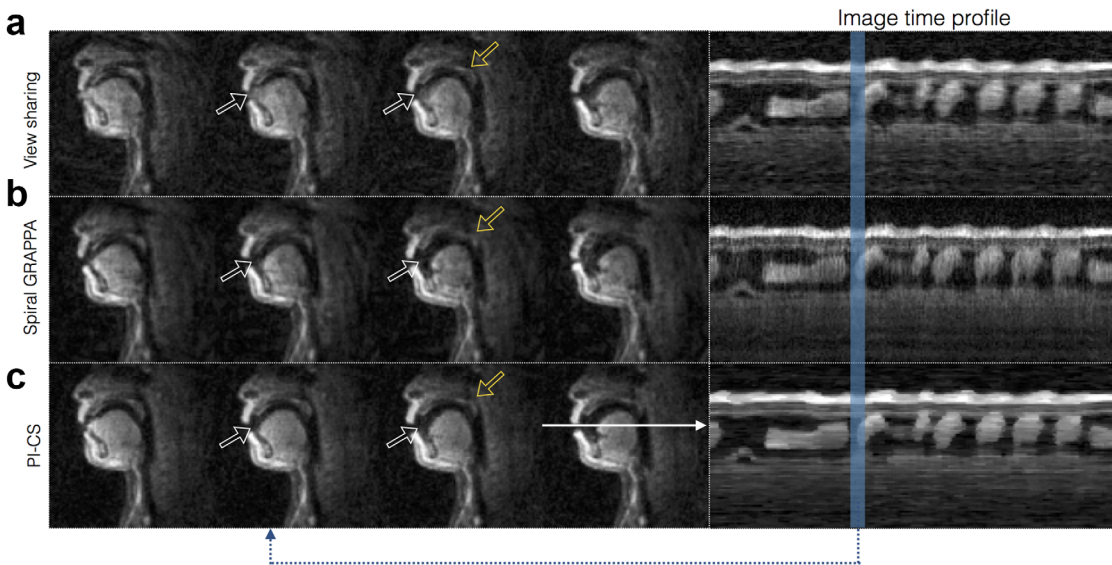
RT-MRI of beat boxing at 55 fps with (a) view sharing, (b) spiral GRAPPA, and (c) PI-CS. The dynamic time series corresponded to the 5-second snippet of a free-style beat-boxing task. The last column shows the image time profile as marked by the solid white arrow. Columns 1 to 4 show the dynamic images of the time instance marked on the first column. In comparison to PI-CS, and spiral GRAPPA, view sharing resulted in temporal blurring of fast articulatory dynamics. For instance, the rapid inward movement of the tongue tip is captured with better fidelity in the spiral GRAPPA and PI-CS methods when compared to view sharing (see white arrows). Similarly, subtle movements of the velum are blurred with view sharing in comparison to spiral GRAPPA and PI-CS (see yellow arrows). PI-CS has improved signal to noise attributed to inherent denoising. Approximate MATLAB (The MathWorks, Inc., Natick, MA, USA) latency times were: view sharing (14 ms/frame); spiral GRAPPA (116 ms/frame); and PI-CS (17.5 mins to jointly reconstruct 5 secs of RT-MRI data).
